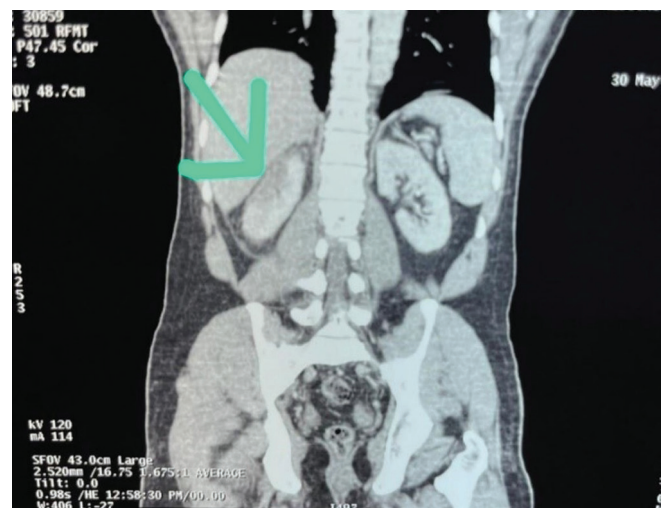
CT abdomen showing infarct in the right kidney. The green arrow marks the wedge-shaped hypodense lesion in the cortex of the upper pole of the right kidney. CT = computed tomography.
